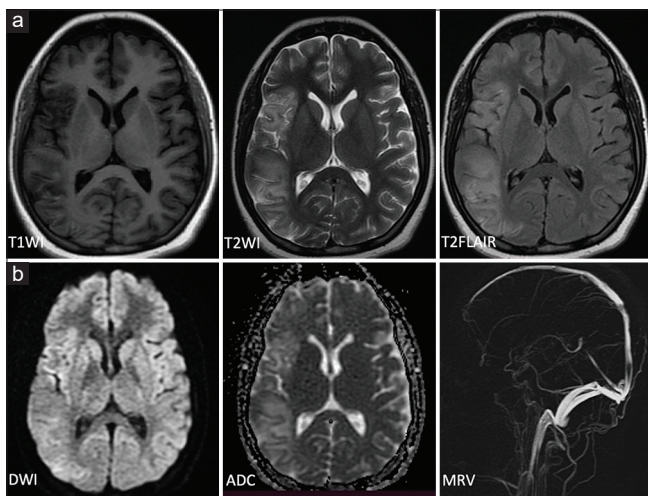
Brain imaging at 1 week. (a) Magnetic resonance axial T1W image shows hypointensity and effacement of sulci in the right cerebral hemisphere. T2W and T2 FLAIR images show hyperintensity in the right cerebral hemisphere. (b) DWI shows hyperintensity in the right cerebral hemisphere, with corresponding hypointensity in the ADC image, suggesting acute infarct. MRA shows narrowing right middle cerebral artery M2 segment and paucity of peripheral vasculature. ADC = apparent diffusion coefficient, DWI = diffusion-weighted image, MRA = magnetic resonance angiogram, T1W = T1 weighted, T2W = T2 weighted
